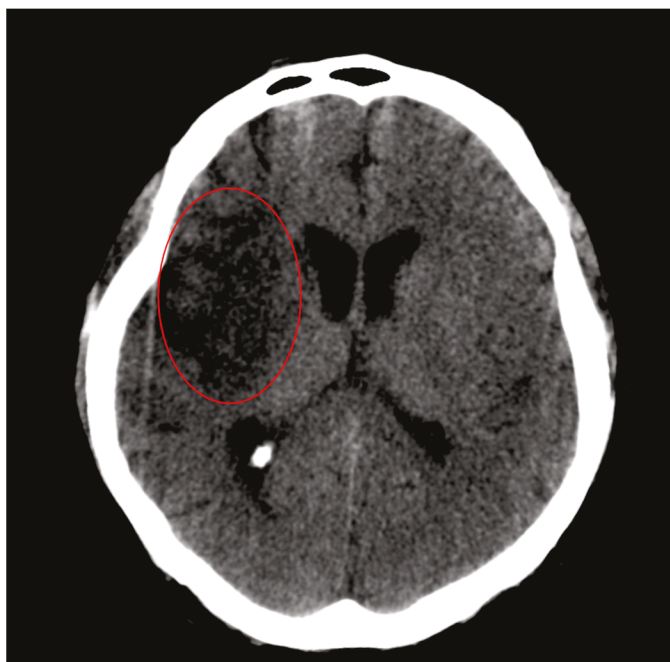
Head CT scan performed at 7 days after MT showed ischemia in the vascularized territory (lentiform nucleus and in the fronto-temporal-insular right lobe) (red circle).
